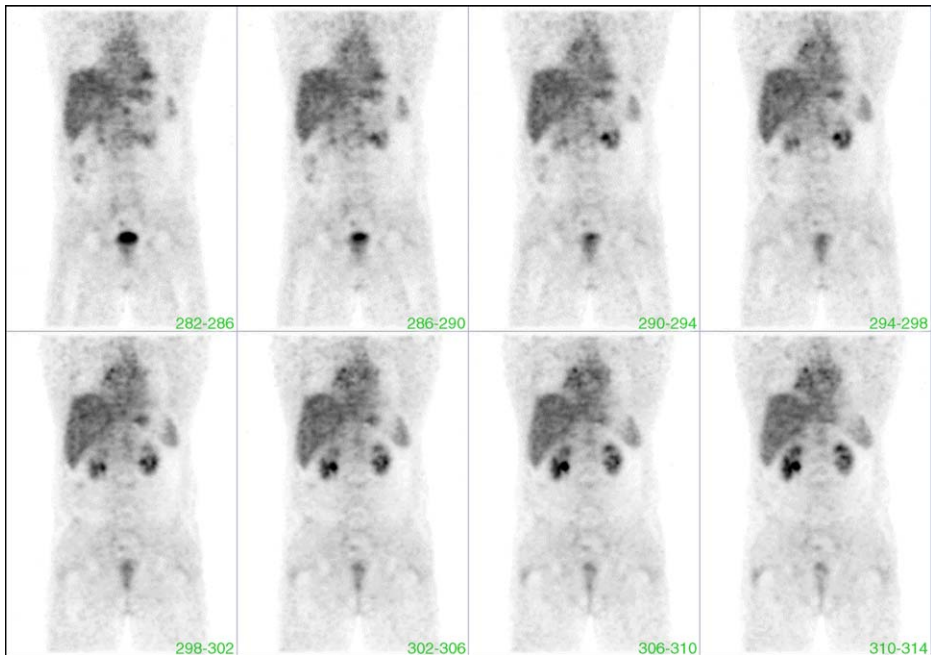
Patient with a diagnosis of germ cell tumor presented with rising CA125. Coronal views of FDG-PET study show two focal areas of increased FDG uptake in the mediastinum suggestive of lymph node metastases.
